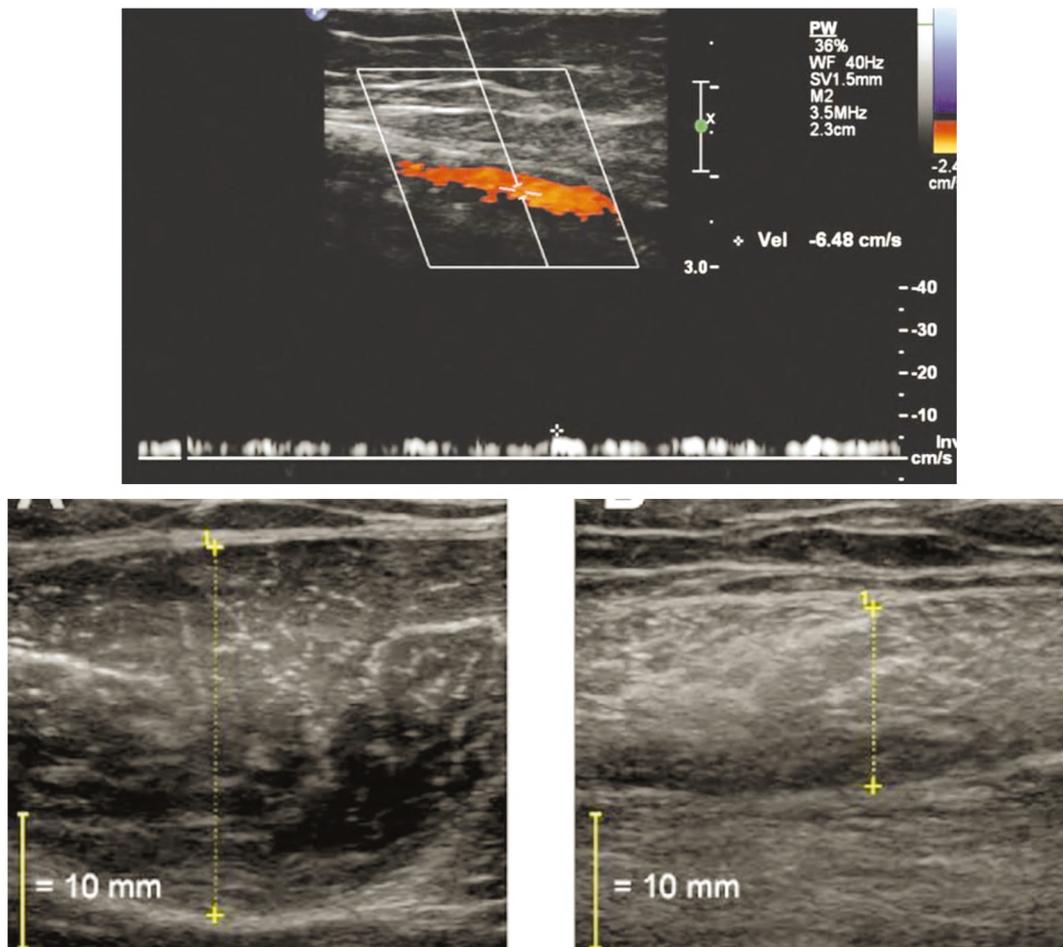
50 years old male patient came to ER ater road traaic accident, ultrasound image shows vascular abnormasities on ultrasonography; decreased arterial diameter and blood flow.
